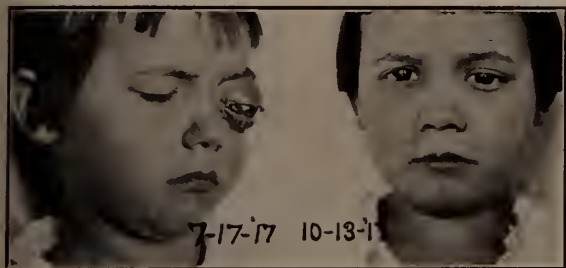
(a) 7/17/17. Sarcoma of left orbit. Duration three months. (b) 10/13/17. Well as a result of Roentgentherapy. No injury to the eye. Still well March 30, 1921.
